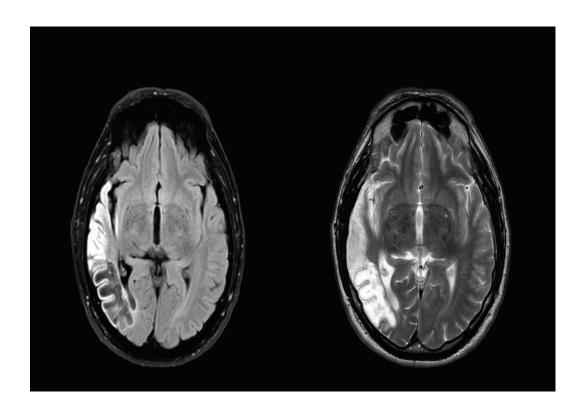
(T1W), 4. (T2W), and 5. (T2W) Show brain MRI 4 days after the onset of symptoms.
